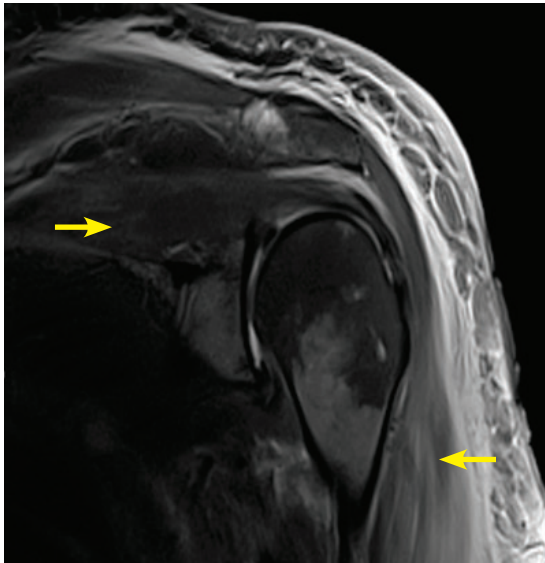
Magnetic resonance imaging without contrast showing diffuse soft-tissue edema (arrows) consistent with cellulitis and myositis of the deltoid and supraspinatus muscle.
